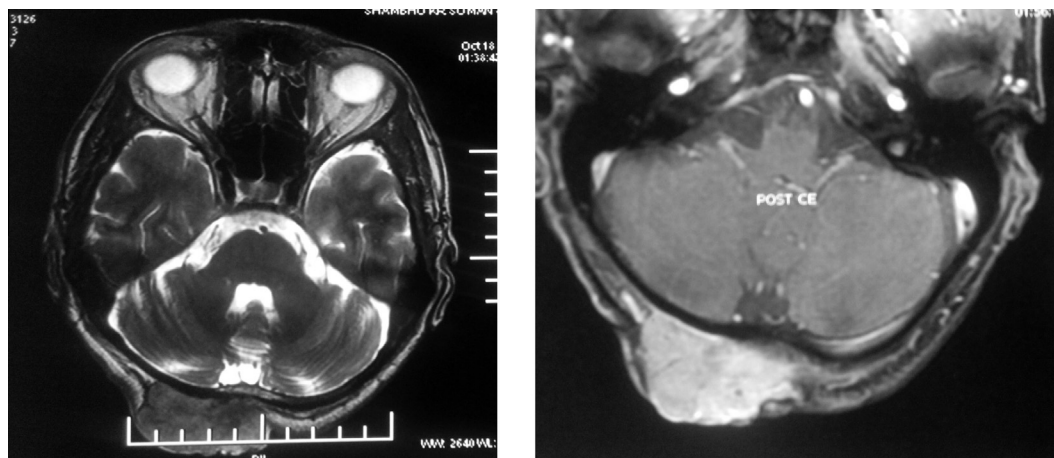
Magnetic resonance imaging of the patient showing a well margined contrast enhancing lesion in the right occipital region.
